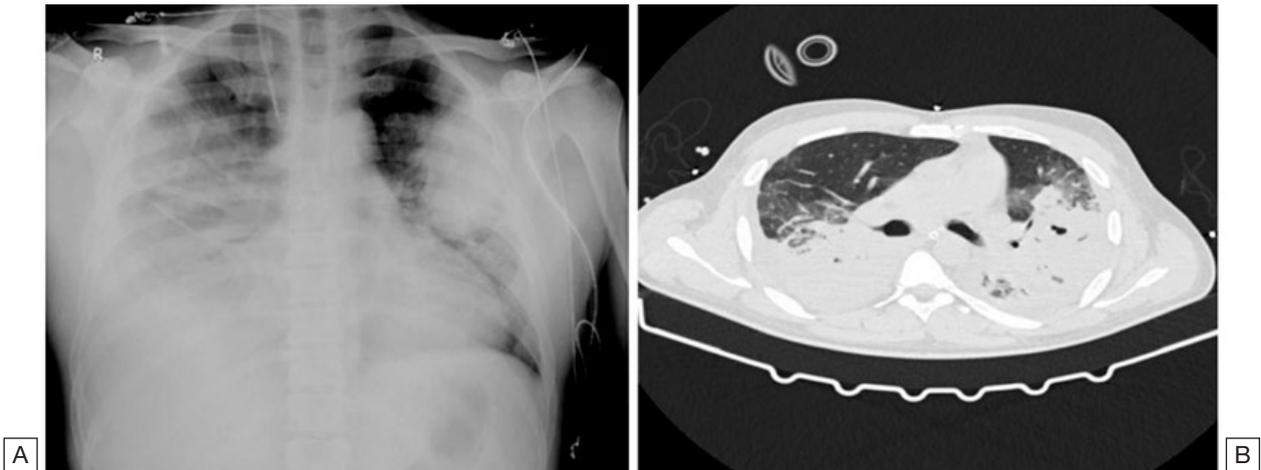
Chest imaging on the 5th day of admission. [A] - Chest radiograph; [B] - Chest CT.
